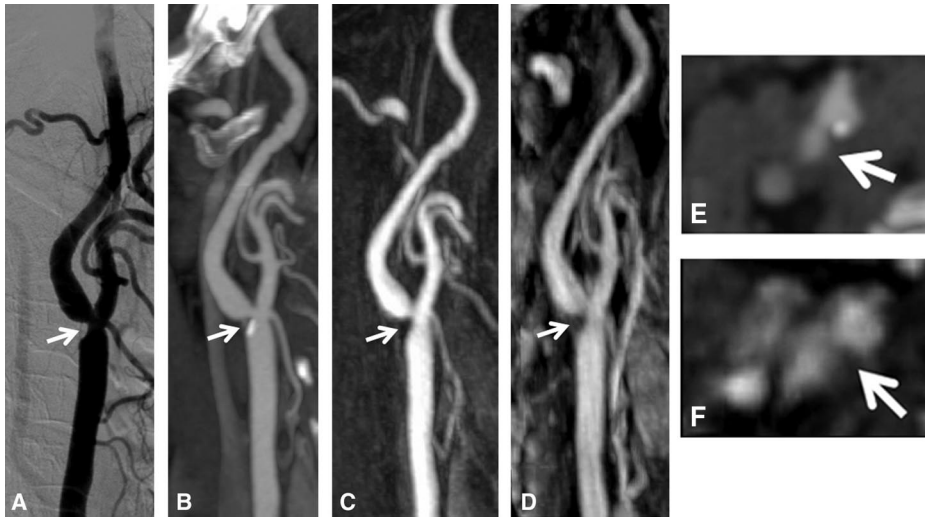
DSA (A) reveals narrowing of the lumen (NASCET grade III) of the right ICA because of a focal stenosis caused by a smooth plaque (arrows). Stenosis grading was correctly reported on CTA (B), as well as on CE-MRA FP (C) and SS (D) images. Coaxial reformations from CTA (E) and SS MRA (F) show the lumen at the point of maximum stenosis (arrows). In this case the readers assigned a score of 1 for the usefulness of the SS acquisition (SS images provide similar information to FP images enabling increased confidence).
